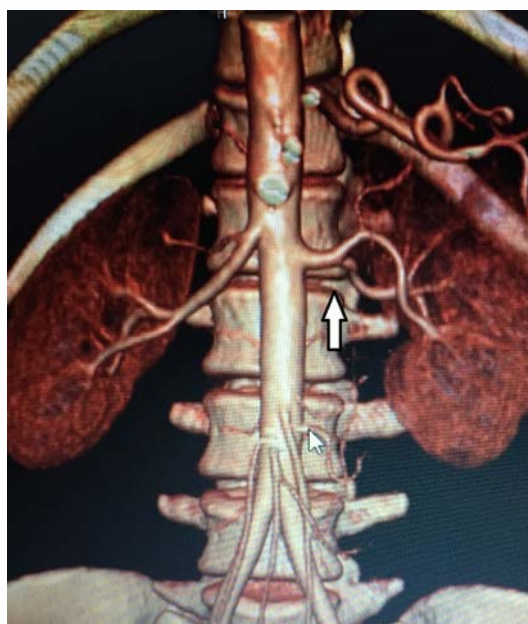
CT angiography of the donor of recipient A (the arrow shows early branching of the artery trunk)
